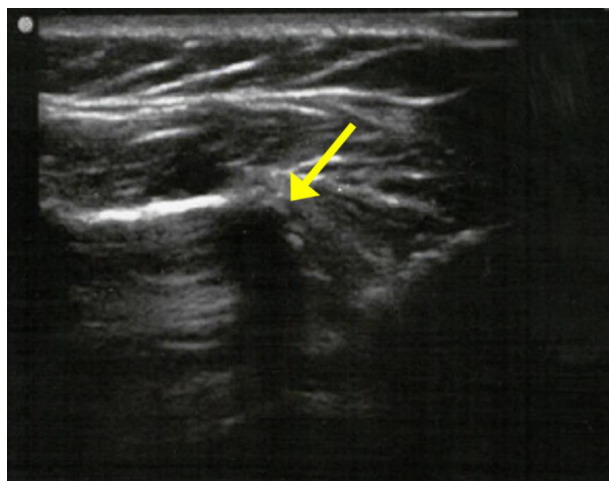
A limited ultrasound evaluation revealed a hypoechoic lesion (shown by yellow arrow) in the area of her pain.
